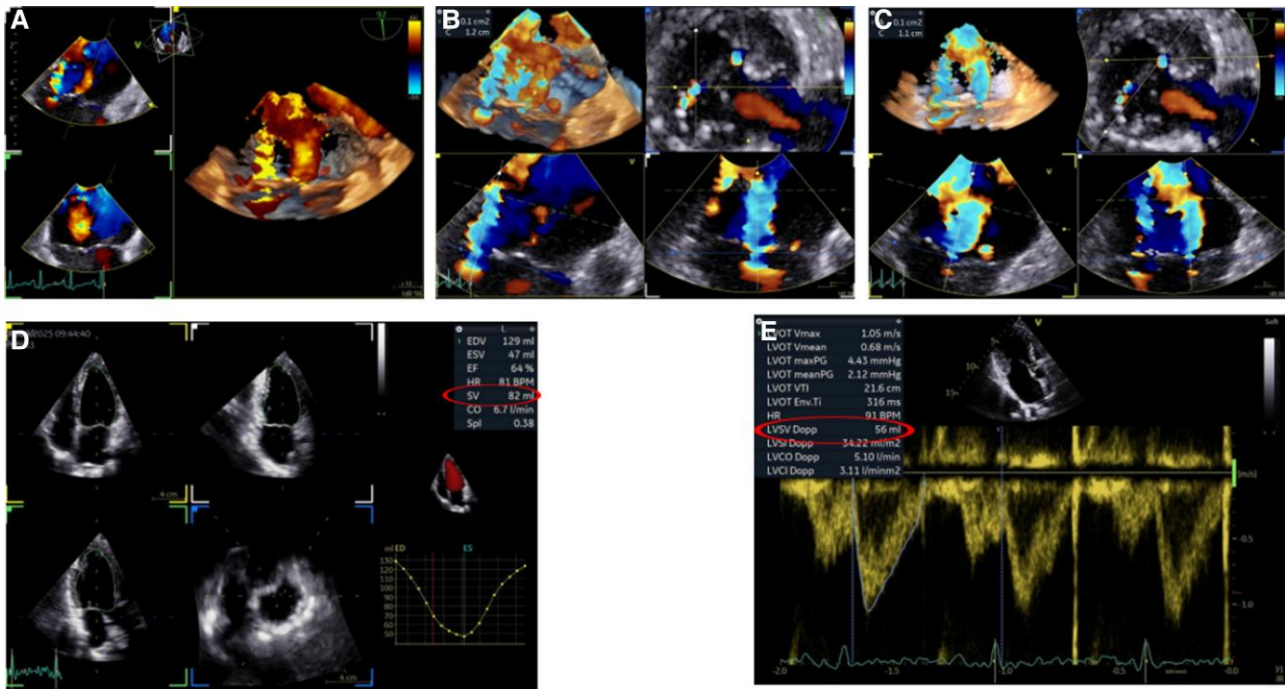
3D VCA and volumetric method for MR quantification. (A) 3D TEE cropped view showing MR in a bileaflet prolapse characterized by two predominant central–medial jets. (B) and (C) 3D VCA of the two main jets. (D) and (E) The volumetric method indirectly quantifies MR, and its results are particularly useful in the case of multiple jets: RV is calculated as the difference between total stroke volume derived from 3D LV semi-automated quantification (red circle, panel D) and forward stroke volume by pulsed-wave Doppler (red circle, panel E).
